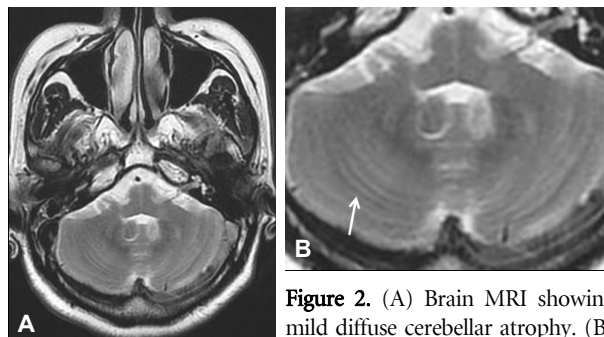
(A) Brain MRI showing mild diffuse cerebellar atrophy. (B) More prominent folia markings (arrow) are noted in the magnified image.
